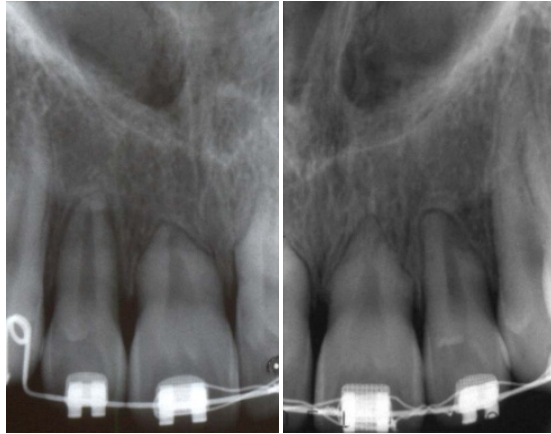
(a, b). Periapical radiographs showing root resorption of superior incisors.
